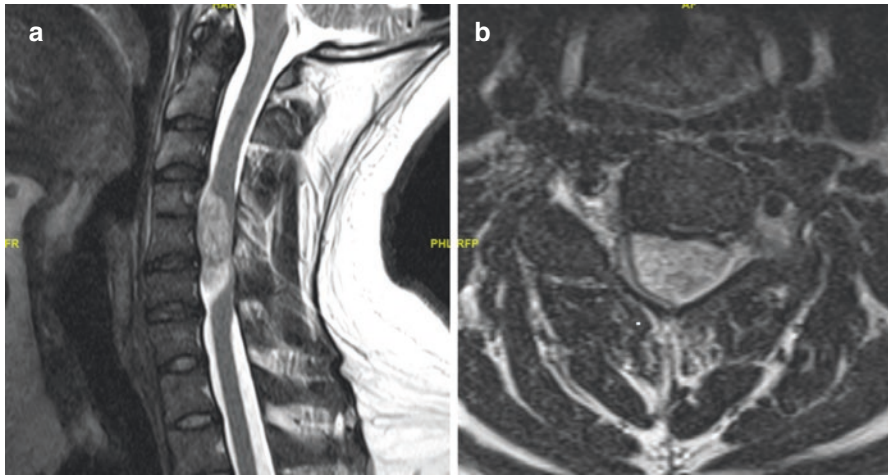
Cervical Spine MRI. Pre-operative T2 sagittal (a) and axial (b) MRI images of the cervical spine showing a large intradural, extramedullary mass from C4–C6 with extension into the left neural foramen, consistent with a nerve sheath tumor
